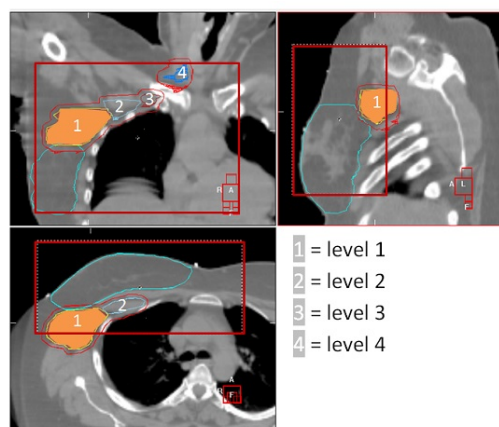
reference CT with ROI in red and an example of a SROI of level 1 in orange. SROI of level 2,3, and 4 are not shown in figure 1.
